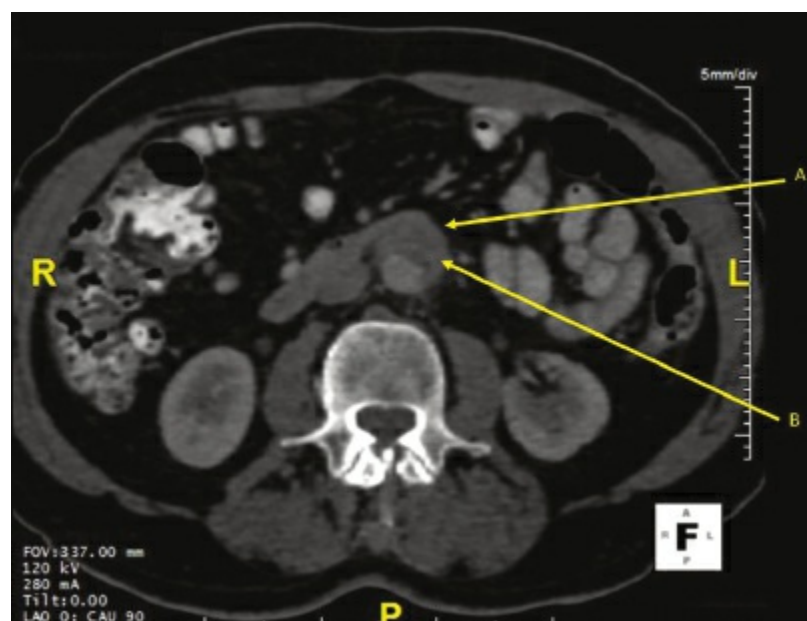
CT scan demonstrating loss of tissue planes around the artery (A), with small foci of air (B) suggesting a mycotic aneurysm.
